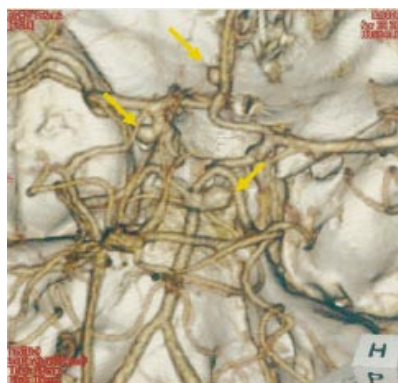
Computed tomographic angiography shows aneurysms of the left internal carotid-posterior communicating artery, left anterior communicating artery, and right posterior cerebral artery (arrows).
